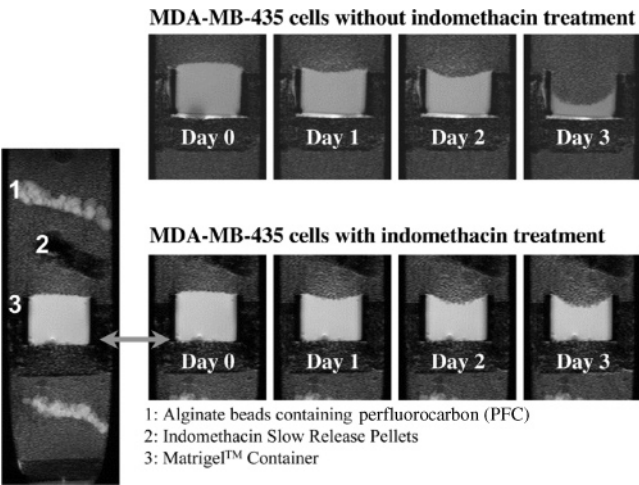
T_1 -weighted ^1H MR images comparing the degradation of the ECM gel by MDA-MB-435 cells under control conditions (top panel) and during indomethacin treatment (bottom panel). The MR image on the left shows the content of the sample during the indomethacin treatment (0.5 μ M). Adapted from ref 38.
